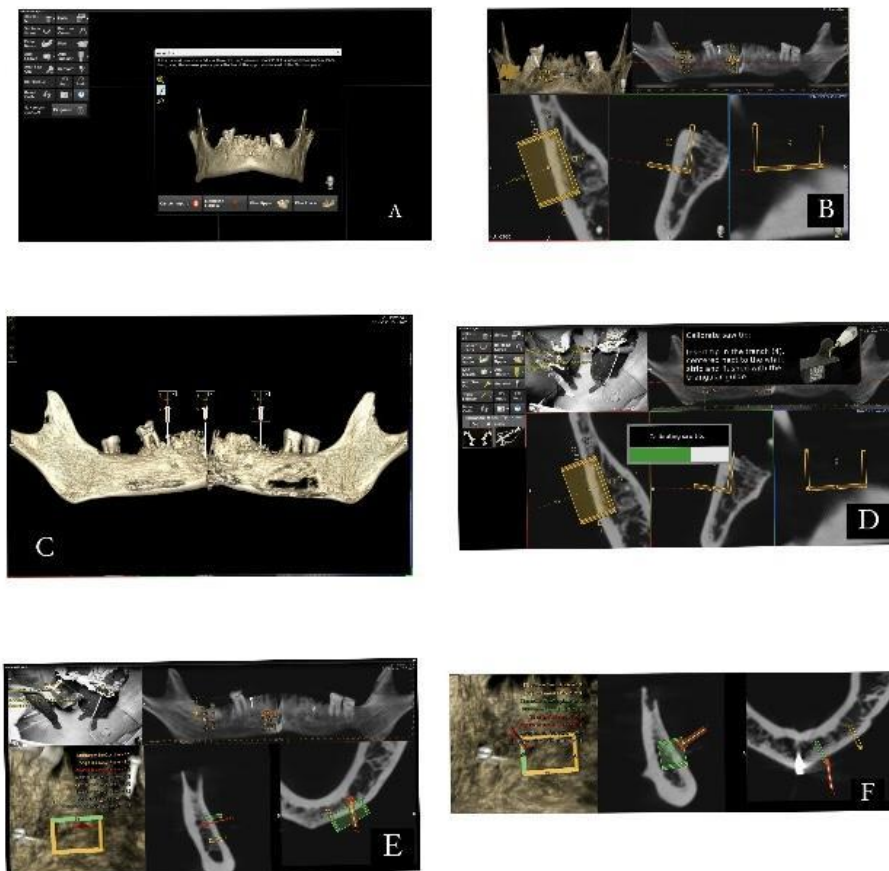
A. CBCT loading in the Navident software, B. Planning of saw cuts (Block graft), C. Points of screws taken for calibration, D. Ongoing saw cut using piezo tips, E. Depth cut as shown on the screen
